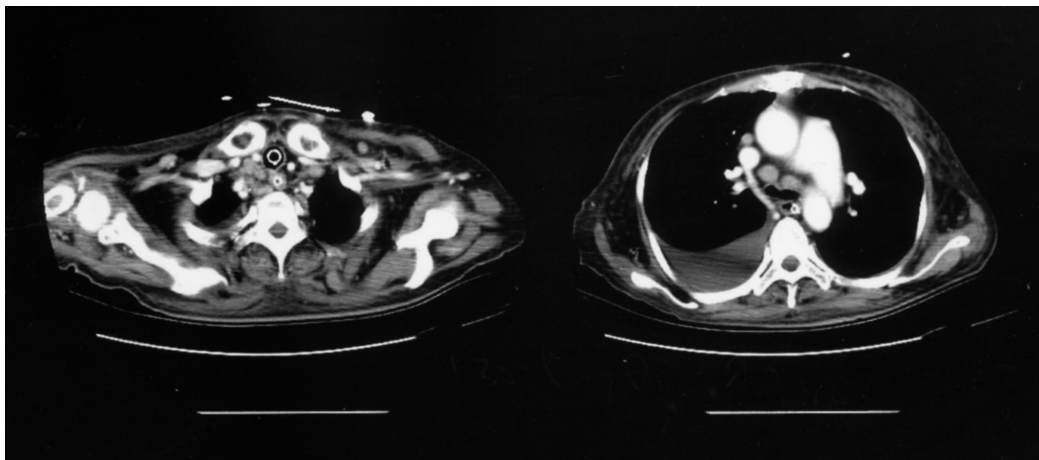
Numerous lymphadenopathies at the bilateral neck and subcarinal area, found in the chest CT.
